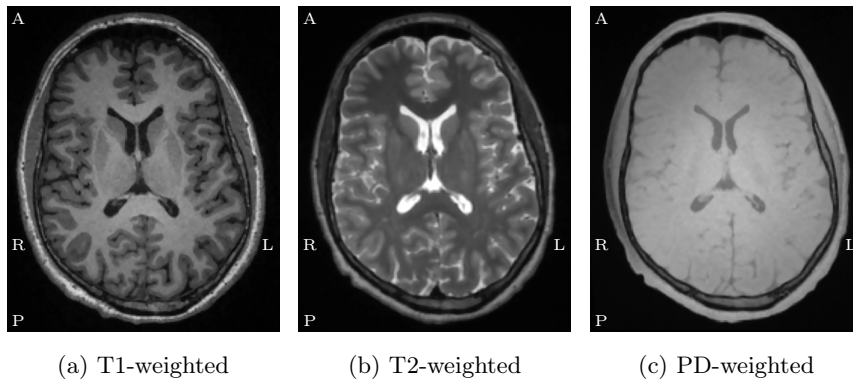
Axial slice of T1-, T2- and PD-weighted MR images of the brain. From [Güllmar, 2008]
